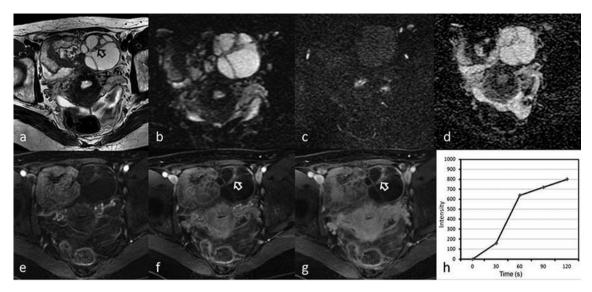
Imaging of a 41-year-old woman affected by mucinous epithelial cystoadenoma (true-negative). a: Axial T2-weighted image showing a multilocular cyst on the left ovary with hypointense solid component. b,c: Axial diffusion-weighted image does not show the presence of a high signal on b-values of 0 and 1000 s/mm² with the apparent diffusion coefficient (ADC) map (d) giving an ADC value of 1.5×10^{-3} mm²/s. e-g: Axial T1-weighted fat-suppressed images showing progressive enhancement in the early phases (e and f) after administration of gadobenate dimeglumine without wash-out in the late phase (g). h: Time-intensity curve obtained on the solid intracystic component.
